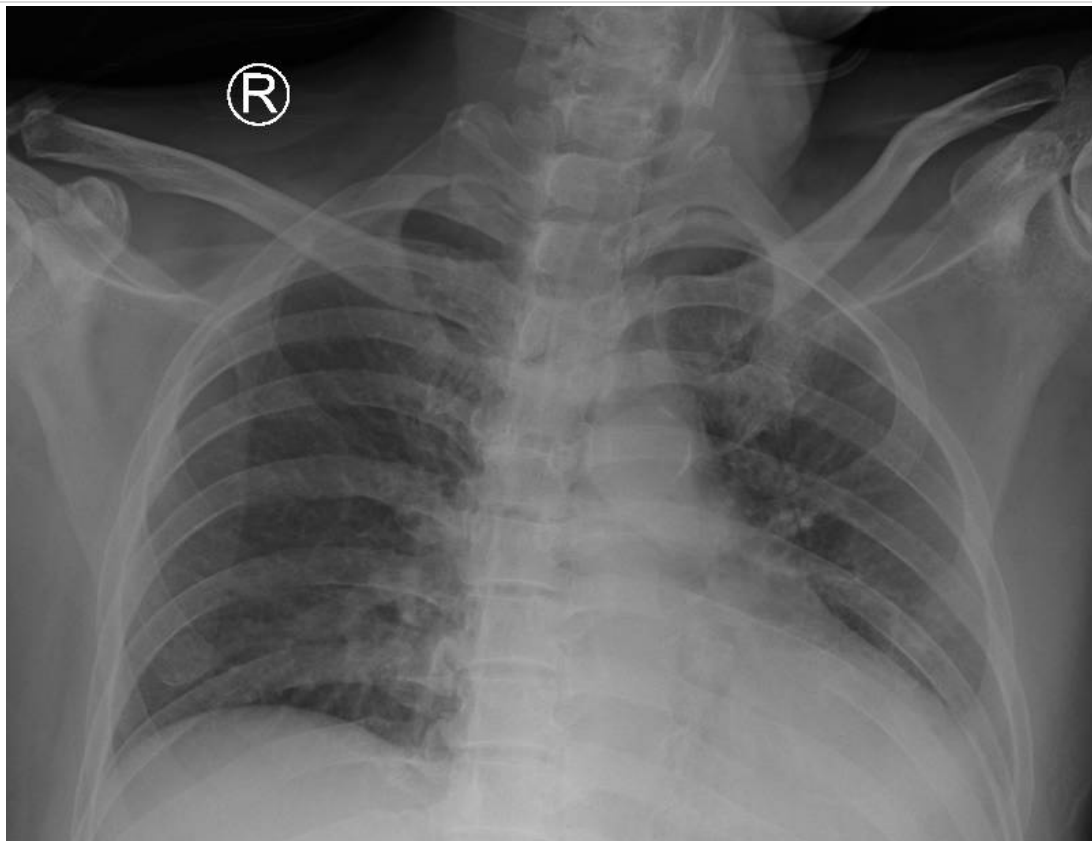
Chest X-Ray result of patient in Case 2. Chest X-Ray showed congestive pulmonary and aortic sclerosis.
